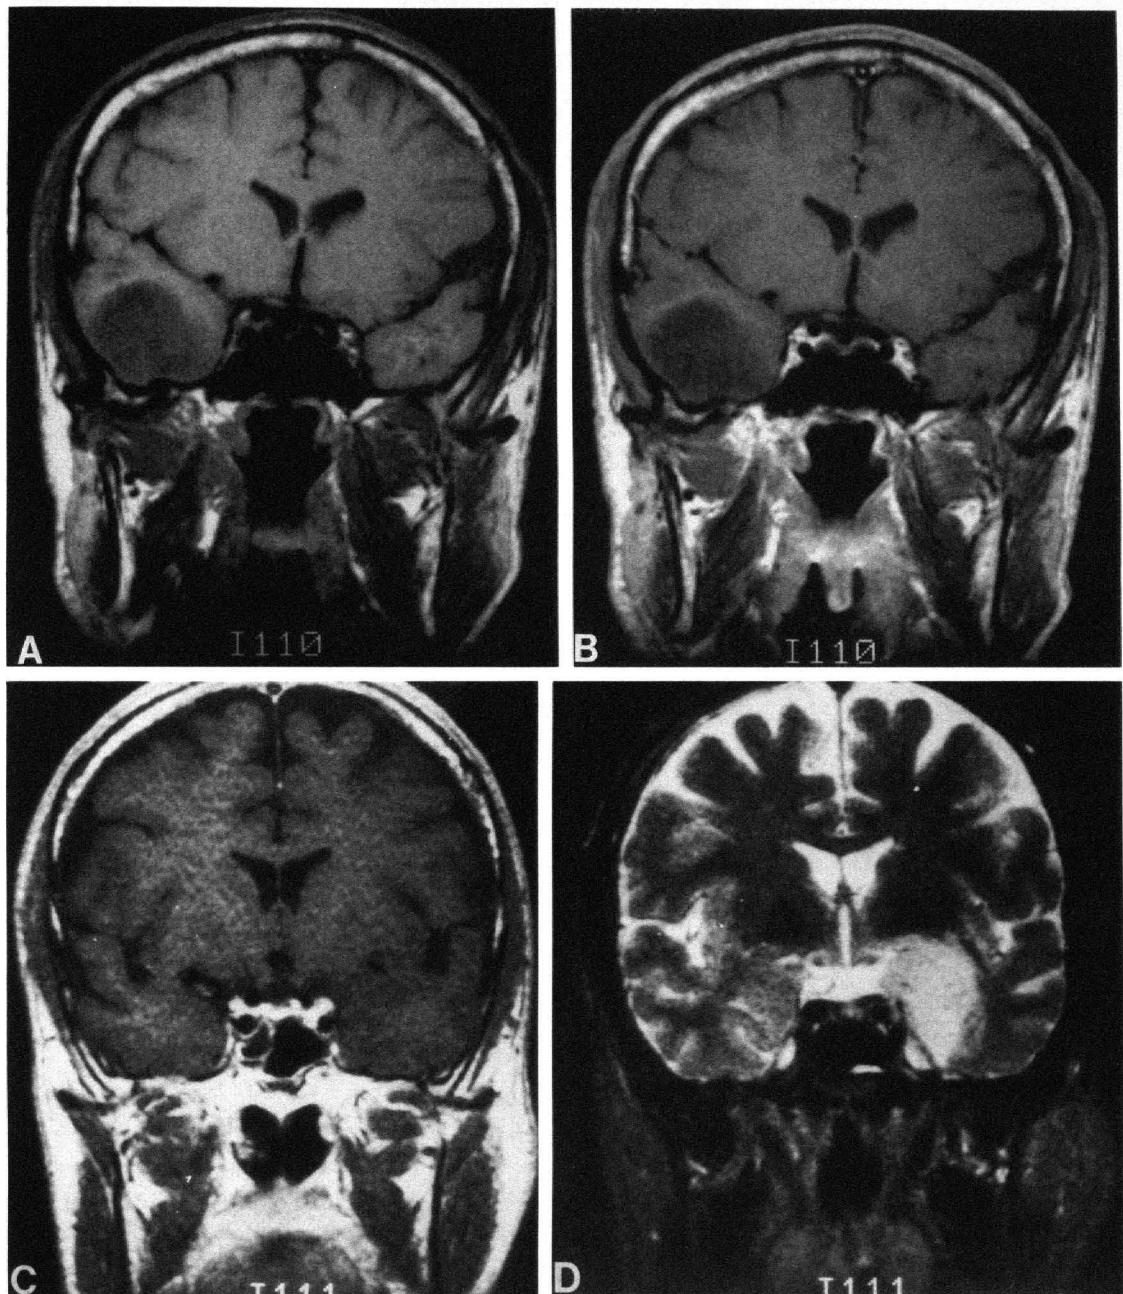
MRI scans of low-grade astrocytoma. A: Case 1: noncontrast, T1-weighted image of right temporal lobe mass. Note the low density of the lesion, with no mass effect. B: Case 1: T1-weighted image after administration of gadolinium, demonstrating no enhancement. C: Case 2: T1-weighted image demonstrating left-temporal-lobe hypodensity with no mass effect. D: Case 2: T2-weighted image demonstrating the characteristic bright signal outlining the tumor.
